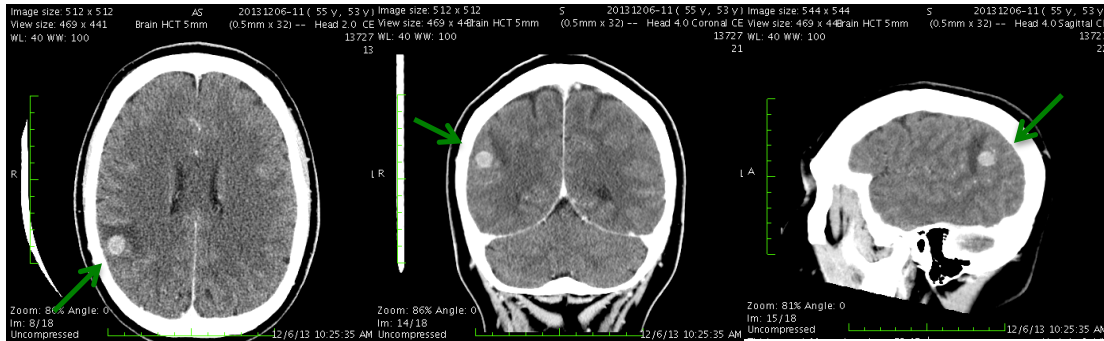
CT of head - lesion at right parietal region - December 2013
